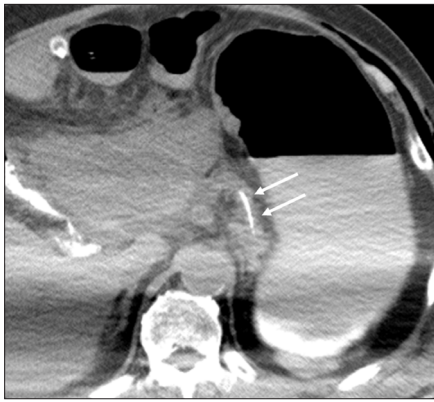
Axial unenhanced CT shows the pancreaticojejunal internal drainage catheter (arrows) placed during the operation of pancreaticoduodenectomy.
